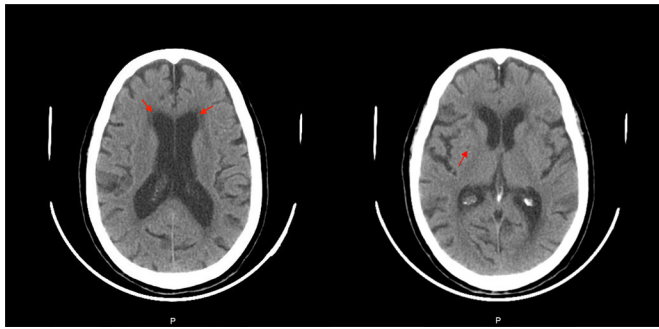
Axial views of cranial CT showing global cortical atrophy. On the left, the red-coloured arrows point to small left and right periventricular hypodensities. On the right, the red-coloured arrow points to right nucleocapsular hypodensities in the right external capsule.
